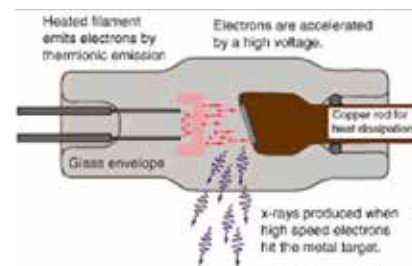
Generation of x-rays using the anode and cathode
